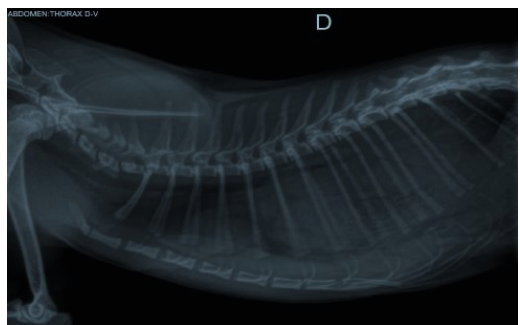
Preoperative X-ray showing the presence of a spleen and intestinal loops in the thoracic cavity.
